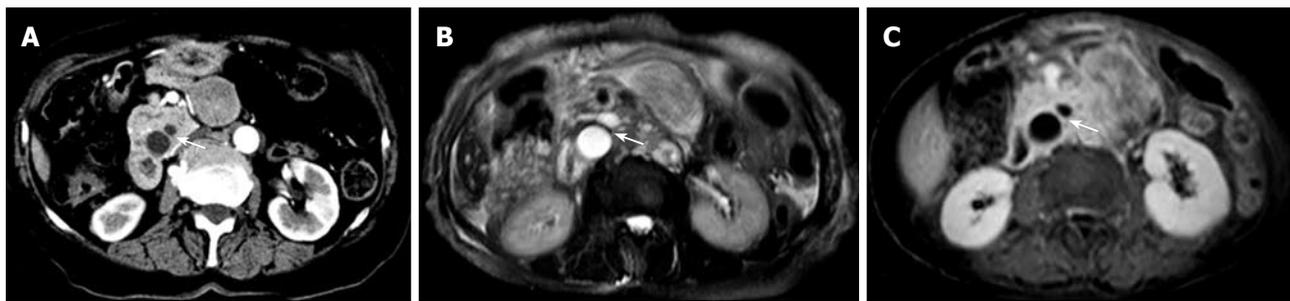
Anomalous junction of the common bile duct and main pancreatic duct. A: CT scan shows the junction of the common bile duct and main pancreatic duct below the level of the uncinus process (arrow); B and C: Axial MR images show the junction of the common bile duct and main pancreatic duct (arrows). (These photographs were processed by Adobe Photoshop Creative Suite 2.).
